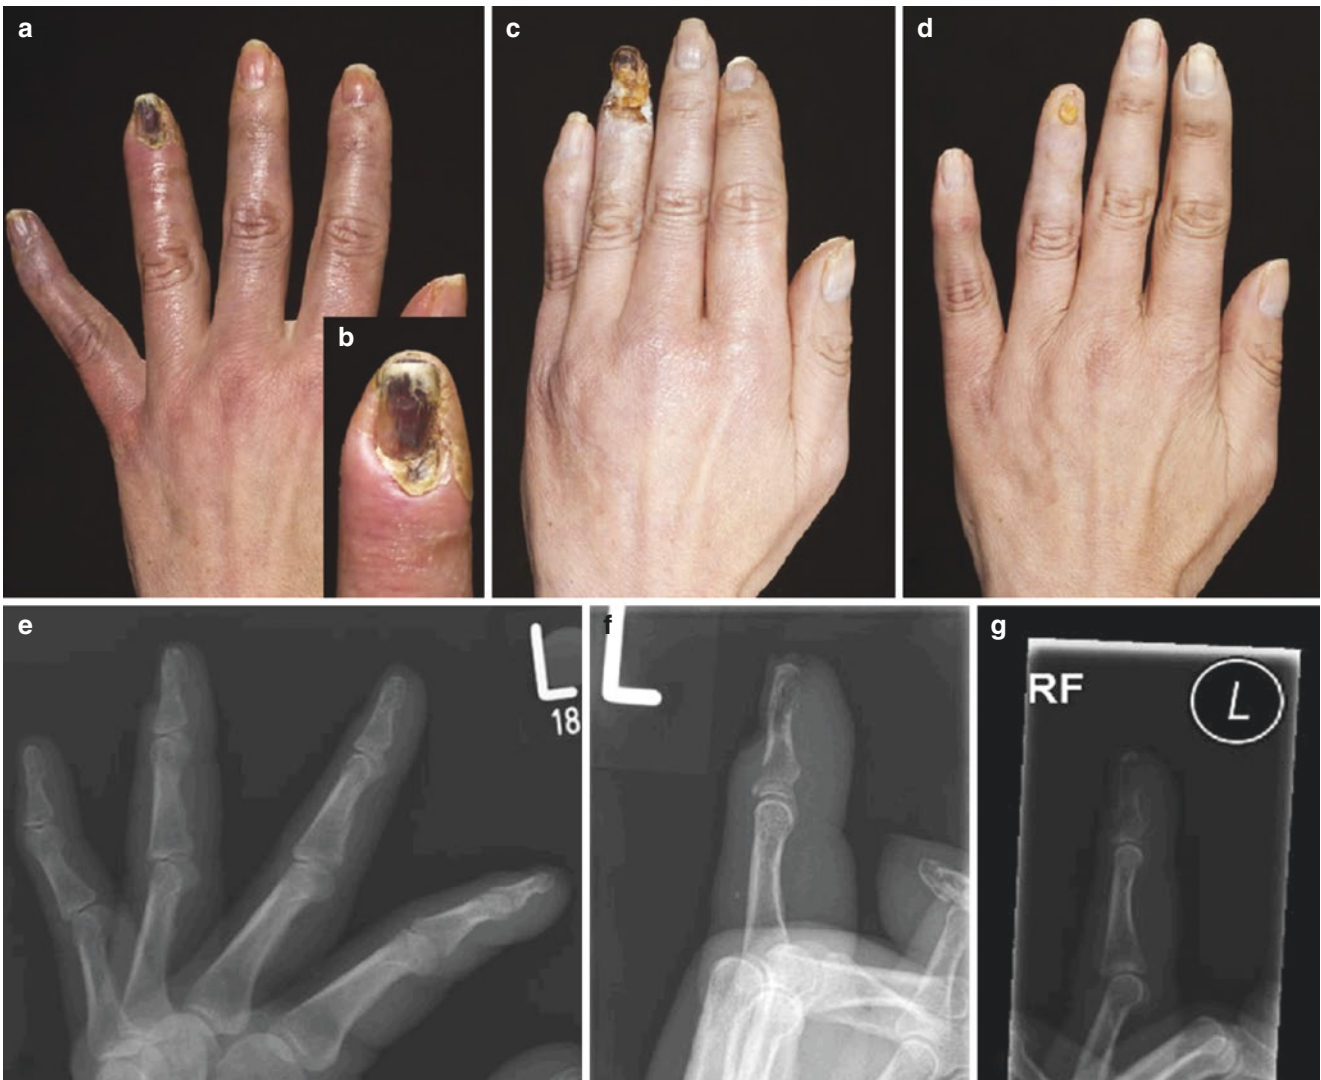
Consequence of severe digital vasculopathy with tissue gangrene and autoamputation. (a–d) (with inset b): Serial panels showed progressive tissue loss with dry gangrene resulting in autoamputation of the left ring fingertip. (e–g) Serial radiographs showed worsening focal area of lucency with cortical erosive irregularity of the distal phalangeal head of the left finger consistent with osteomyelitis
